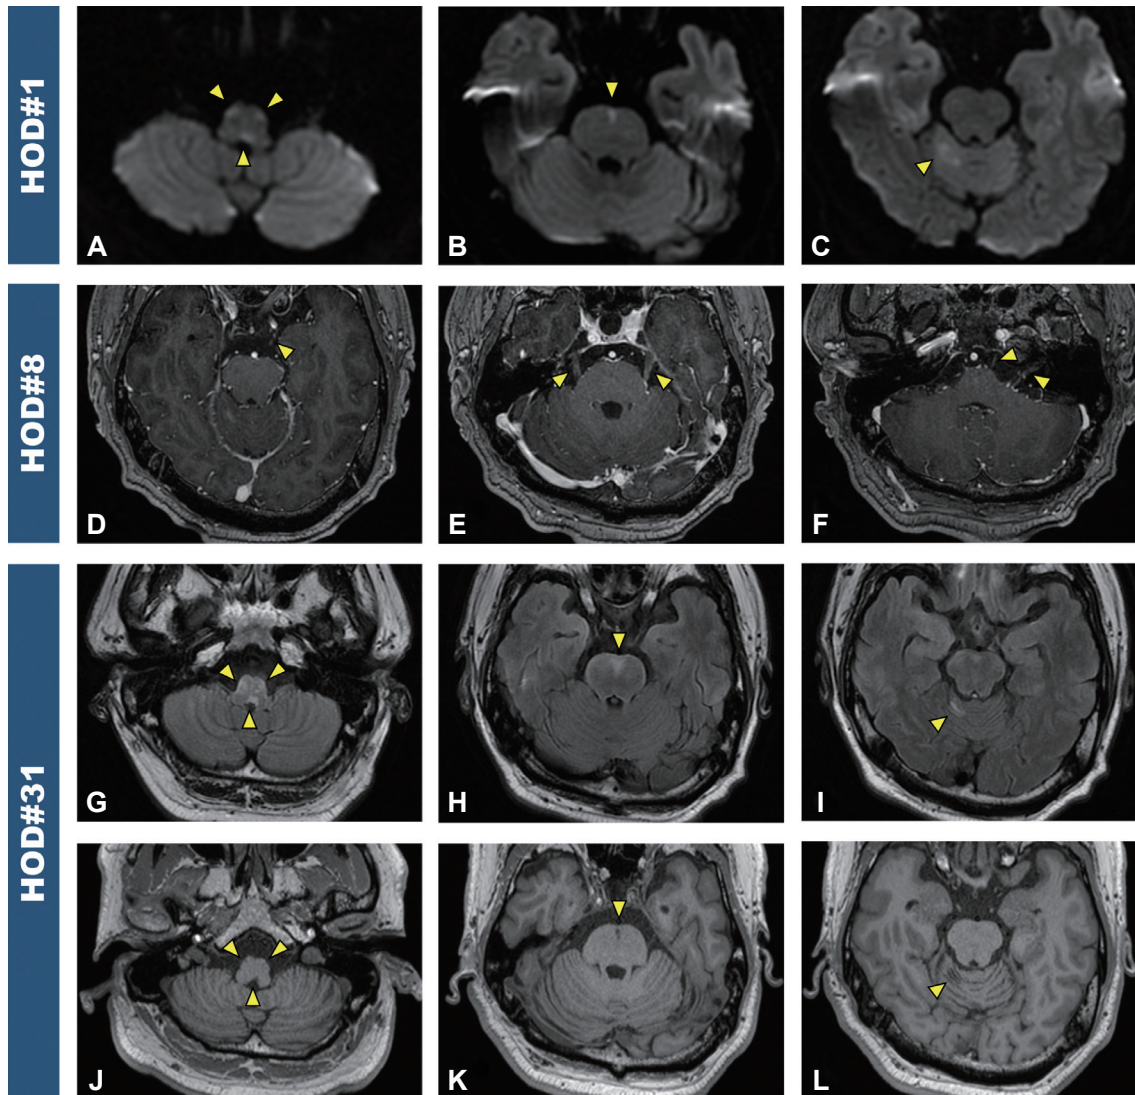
Serial brain magnetic resonance imaging of the patients. A–C: Diffusion-weighted images obtained 1 day after admission show high-intensity lesions in the bilateral ventral medulla and mid-dorsal medulla areas (A, arrowheads), mid-ventral pons (B, arrowhead), and right superior cerebellum (C, arrowhead). D–F: T1-weighted images with gadolinium enhancement obtained 8 days after admission show subtle enhancement along multiple cranial nerves: III (D, arrowhead), V (E, arrowheads), VI, and the VII/VIII complex (F, arrowheads). G–L: Fluid-attenuated inversion-recovery and T1-weighted images obtained 31 days after admission show malacic changes in the medulla (G and J, arrowheads), pons (H and K, arrowheads), and right cerebellum (I and L, arrowheads). HOD, hospital day.
